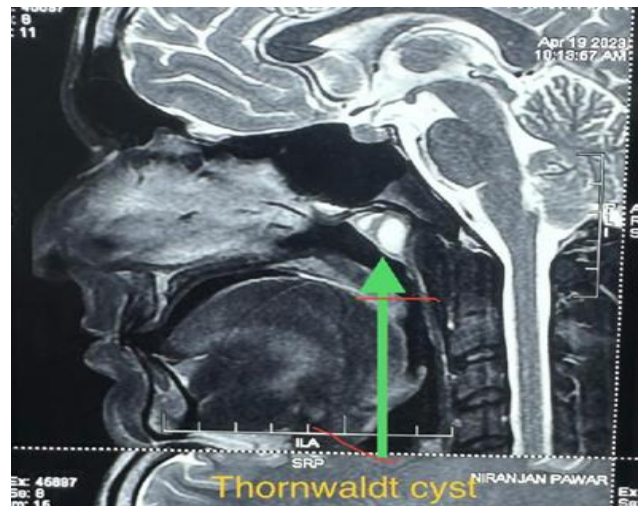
Sagittal section of MRI showing mass occupying filling the nasopharynx, the posterior wall of nasopharynx.
